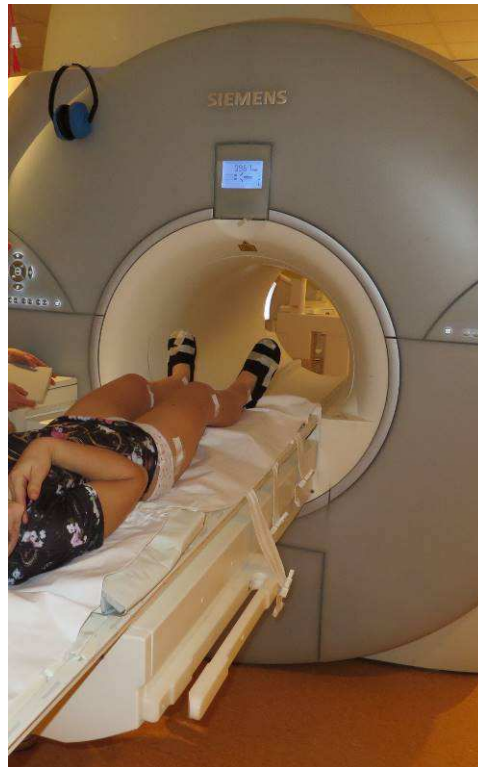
MRI set-up of the first CP patient. MR-visible markers (vitamin e pills) are taped to the locations of the skin where the gait markers are placed. The exact location is marked on the skin. Gymnastic shoes as used on the treadmill are worn to gearantee the same marker location.
